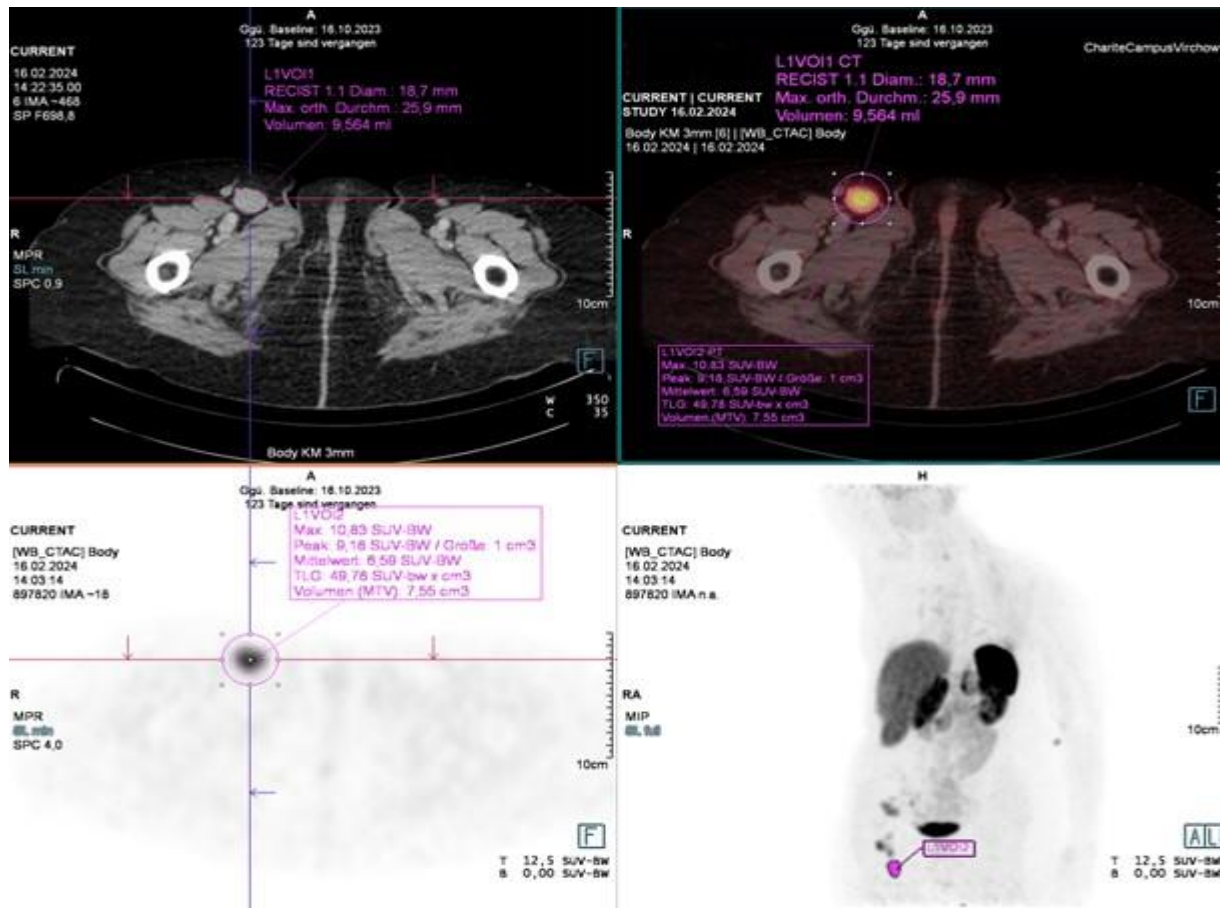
⁶⁸Ga-Dotatoc-PET/CT of a 79 years old woman after lingula resection with NET G1. The CT, coronal fused, PET and Maximum Intensity Projection (MIP) demonstrate PET-positive right sided inguinal lymphadenopathy.
